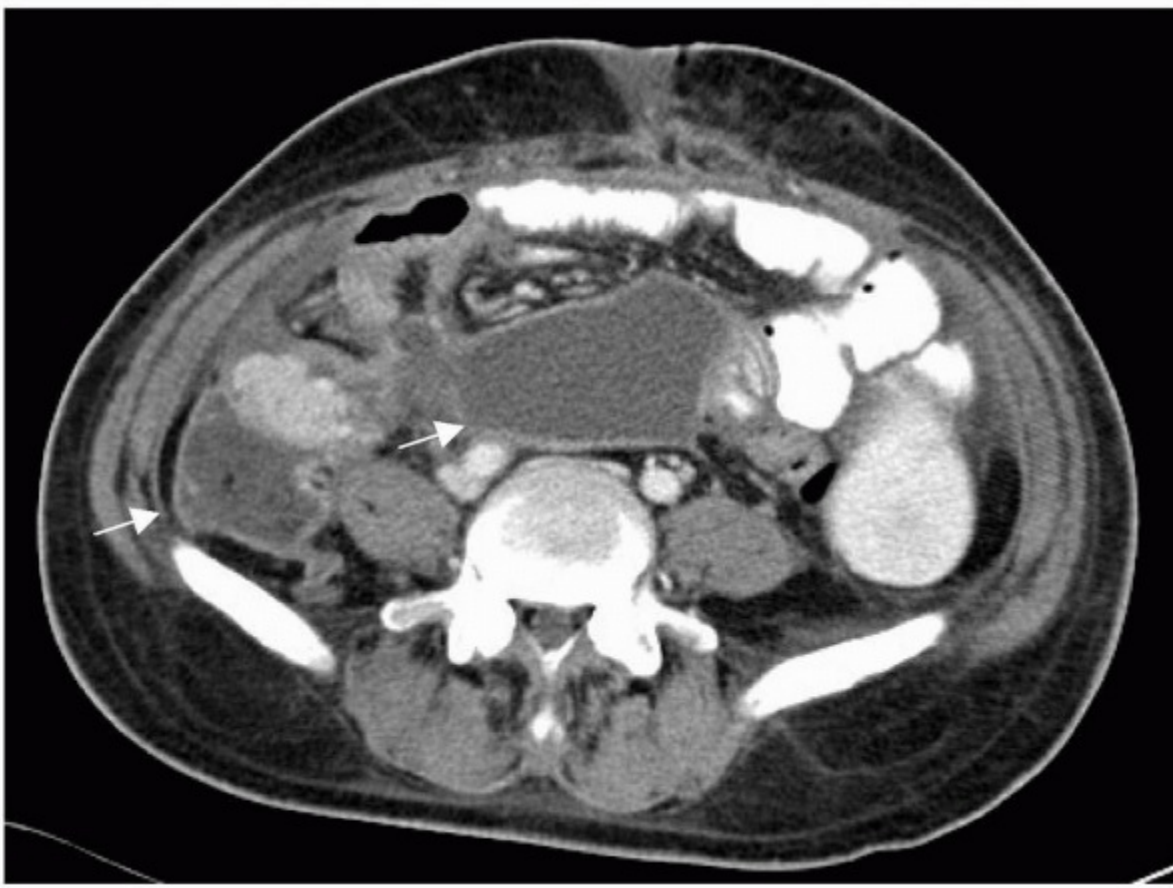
Computed tomography demonstrates peripancreatic fluid collections.
